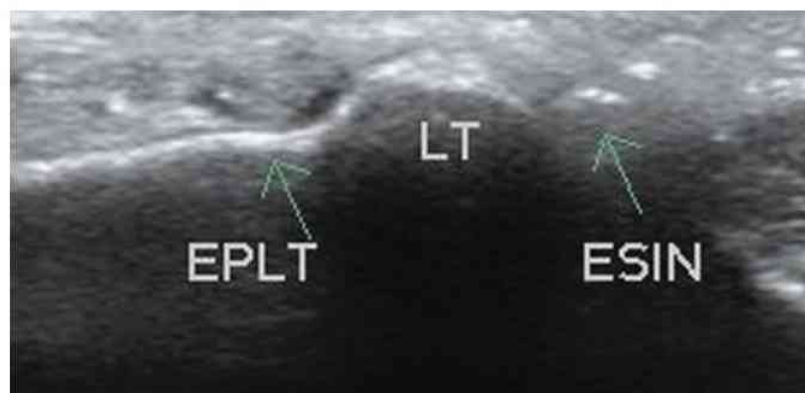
Transverse intraoperative sonographic view of the nail and tendon. ESIN=elastic stable intramedullary nail, EPL=extensor pollicis longus tendon, LT=Lister's tubercle.
